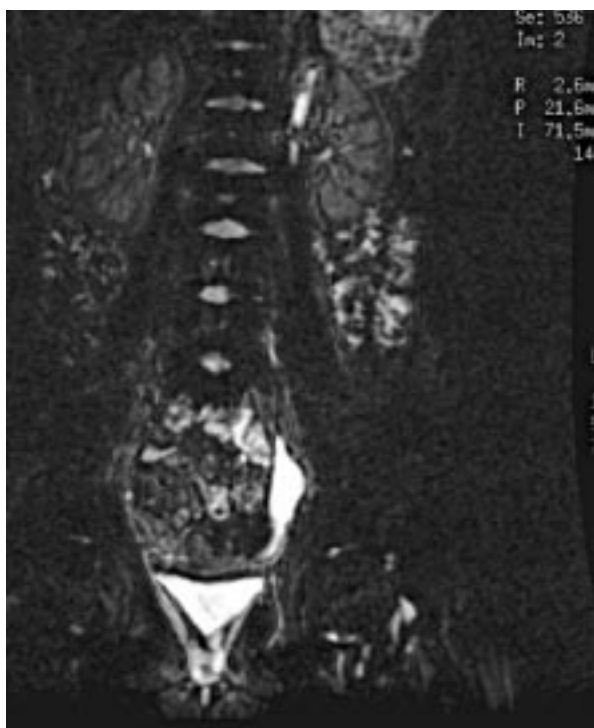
a : MRI diagnosis of ureteral ectopia
